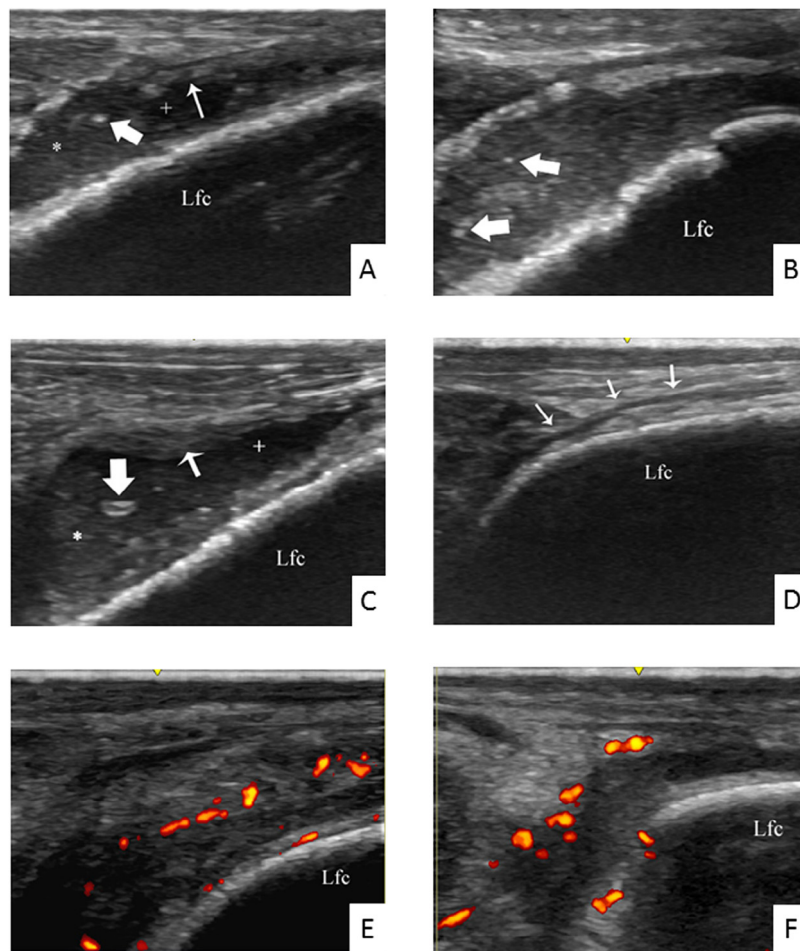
Ultrasound images of the lateral recess of a monosodium urate crystal-injected rabbit knee (a) Increased synovial fluid (+), synovial thickening (*thin arrow*), sand-like material (*) and a bright focus (*thick arrow*). (b) Bright foci (*thick arrows*) inside sand-like material. (c) Increased synovial fluid (+), synovial thickening (*thin arrow*), sand-like material (*) and a hyper-echoic aggregate (*thick arrow*). (d) Normal ultrasound image of the lateral recess of the rabbit knee (*arrows*). (e, f) Power Doppler-detected pathologic flow in the synovial tissue. Lfc = lateral femoral condyle.
